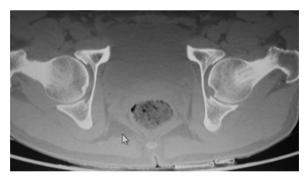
CT scan image in axial section of the femoral neck region of both hips, showing a narrow and sclerotic femoral neck.
